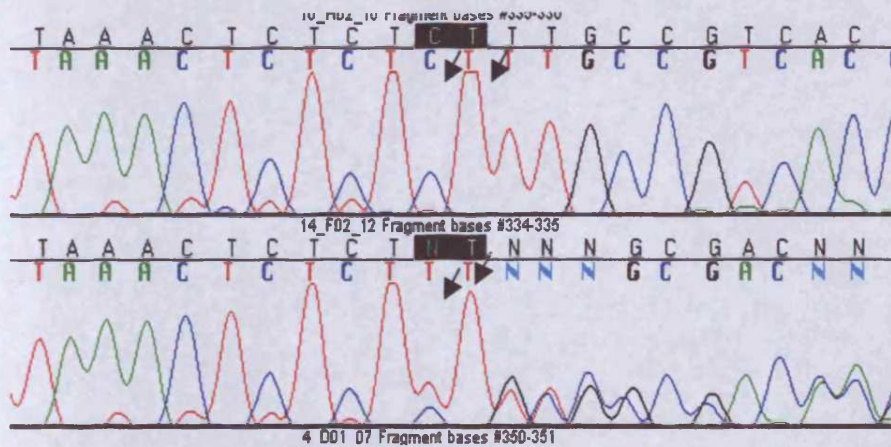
Sequence chromatograms for the *SGPL1* indel 55267-55268delCT showing a non-deletion homozygote in the upper panel and a CT deletion heterozygote in the lower panel.
